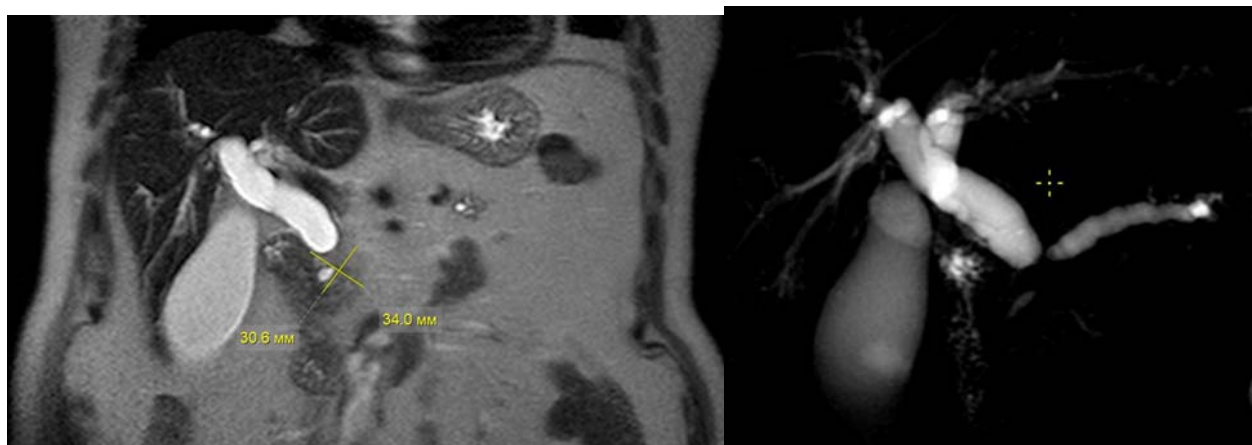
Preoperative analysis of MRI of the abdominal cavity with MR-cholangiography
